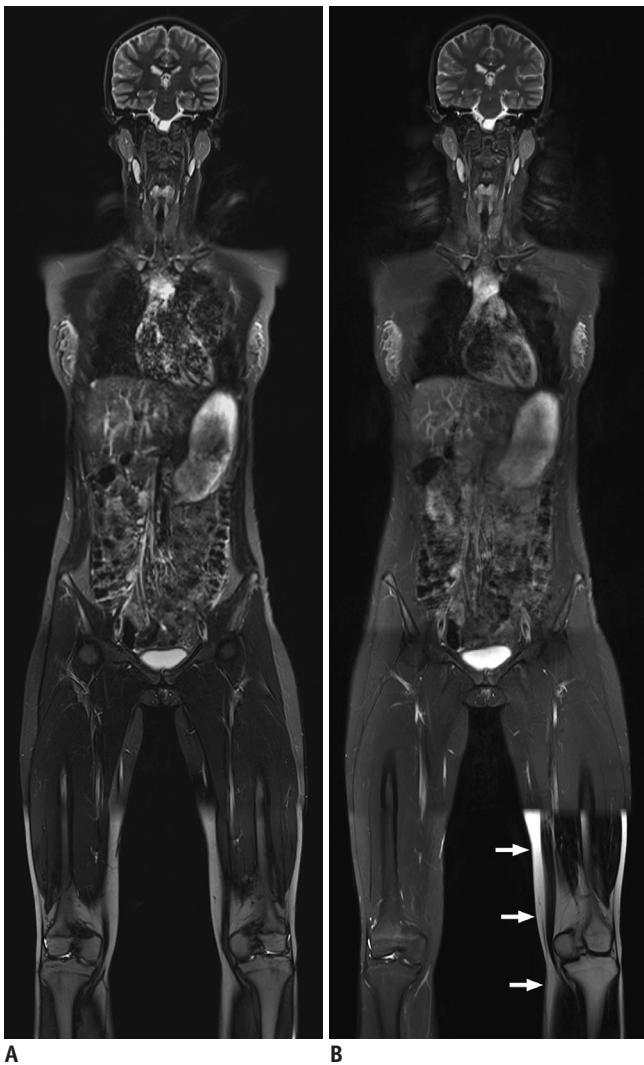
Advantages of T2-weighted Dixon fast spin echo whole-body magnetic resonance imaging (MRI) in adult volunteer. Compared with coronal short tau inversion recovery whole-body MRI obtained at 3T showing incomplete fat suppression (A), coronal T2-weighted fast spin echo whole-body MRI with Dixon-based fat saturation at 3T (B) clearly demonstrates improved fat suppression throughout entire body except for left leg in lowest station (arrows) caused by fat-water swapping error. Motion artifacts in thorax and upper abdomen are less pronounced on T2-weighted fast spin echo imaging (B).
